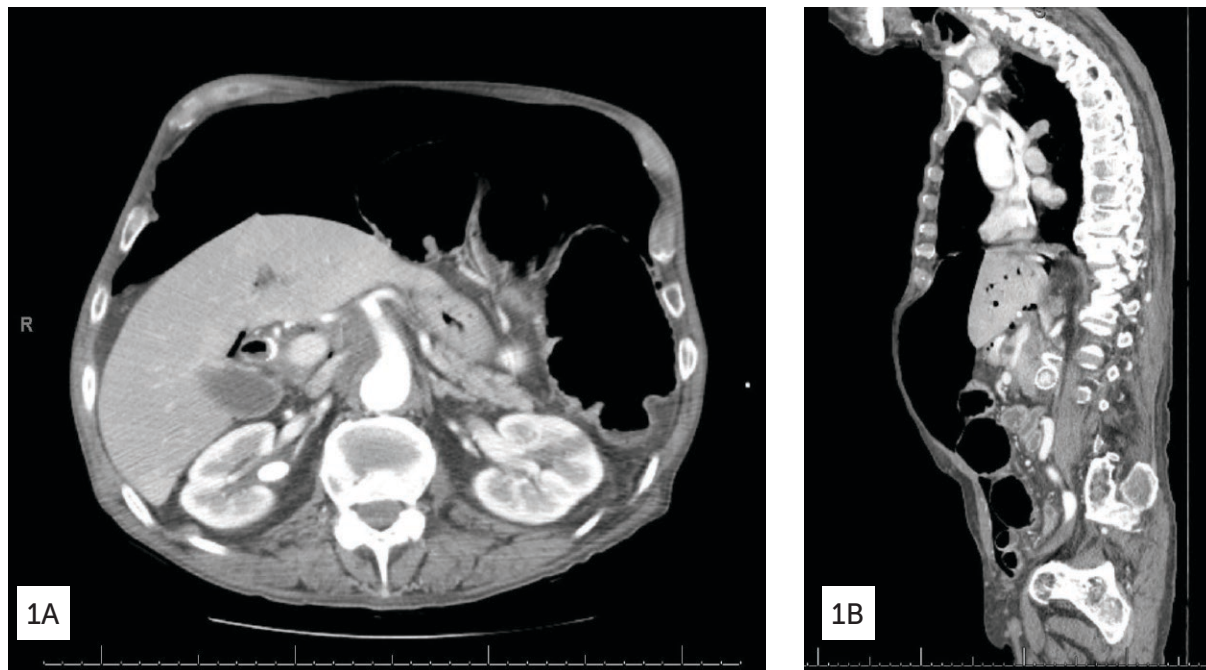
CT abdomen/pelvis with contrast in the axial (1A) and sagittal plane (1B) showing massive pneumoperitoneum.
